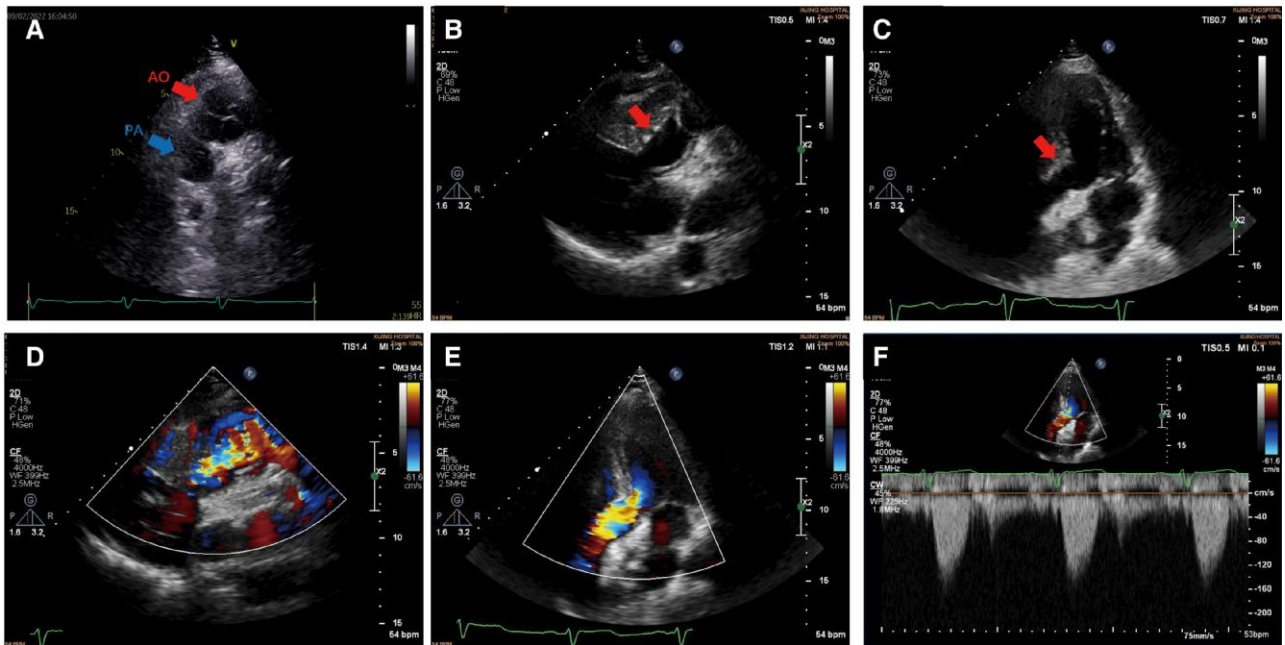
Pre-operative echocardiography. The aorta and pulmonary artery (A), septal hypertrophy (B), the left ventricular outflow tract (C), Doppler flow imaging (D, E), and the gradient at rest of left ventricular outflow tract (F). AO, aorta; PA, pulmonary artery.
